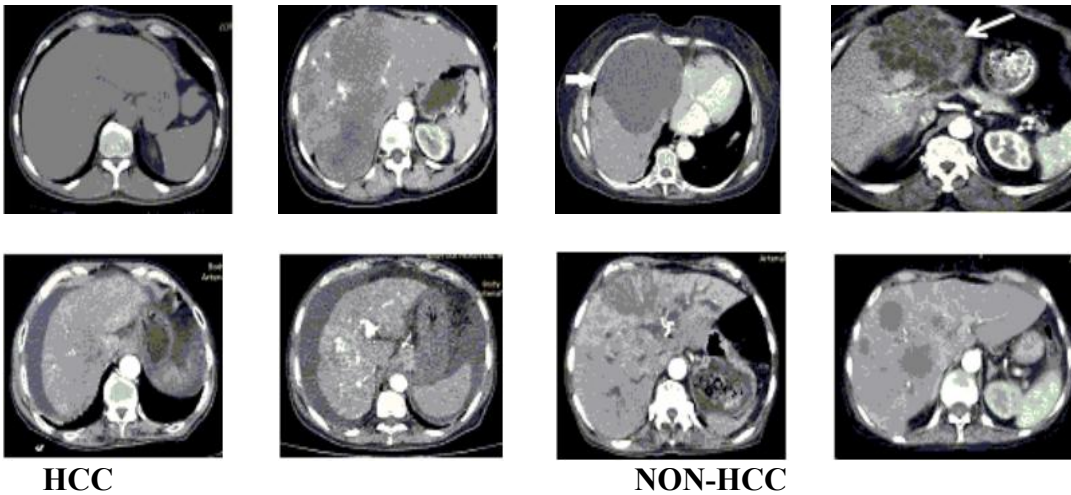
HCC and Non- HCC CT images Dataset
